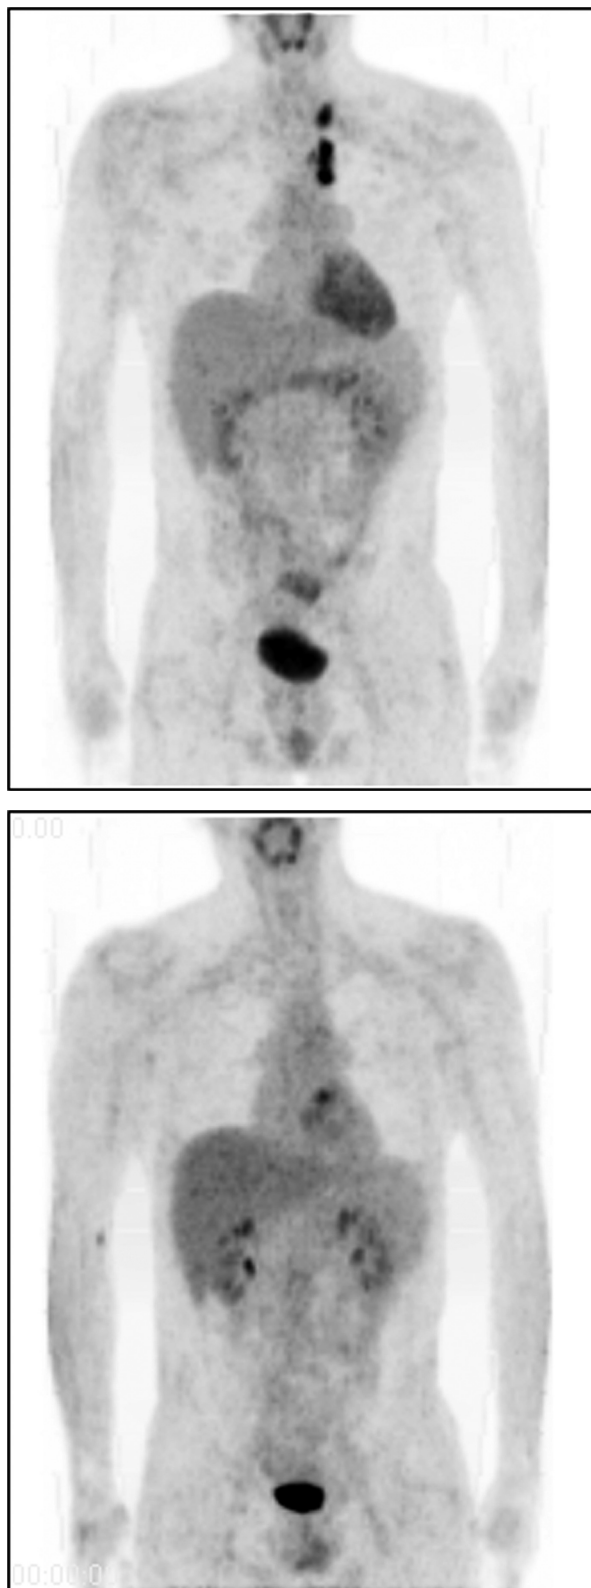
a) Residual mediastinal lymph nodes, SGCT; true positive PET scan after completion of first line chemotherapy with clinical relapse 2 months later. b) True negative FDG PET in the same patient after first cycle of high dose chemotherapy. No residual tumor resection. Clinical follow-up and shrinkage of mediastinal residuals for >3 years
